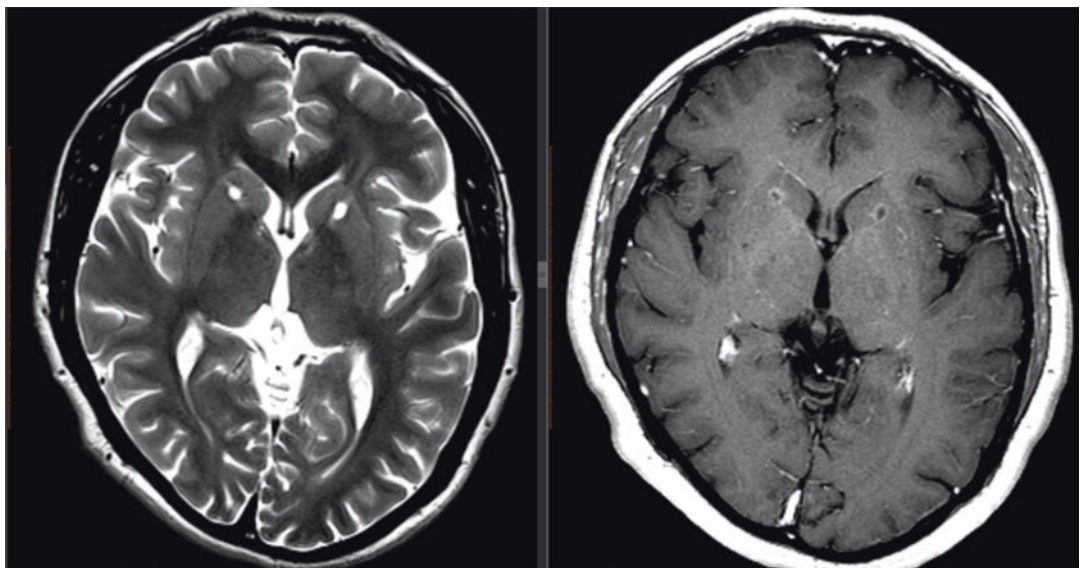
Four-year follow-up axial T2W and contrast-enhanced T1W MR images of the patient with intractable OCD show well-defined bilateral ventral capsulotomies, hyperintense on T2W image and rim-like contrast enhancement on T1W image
